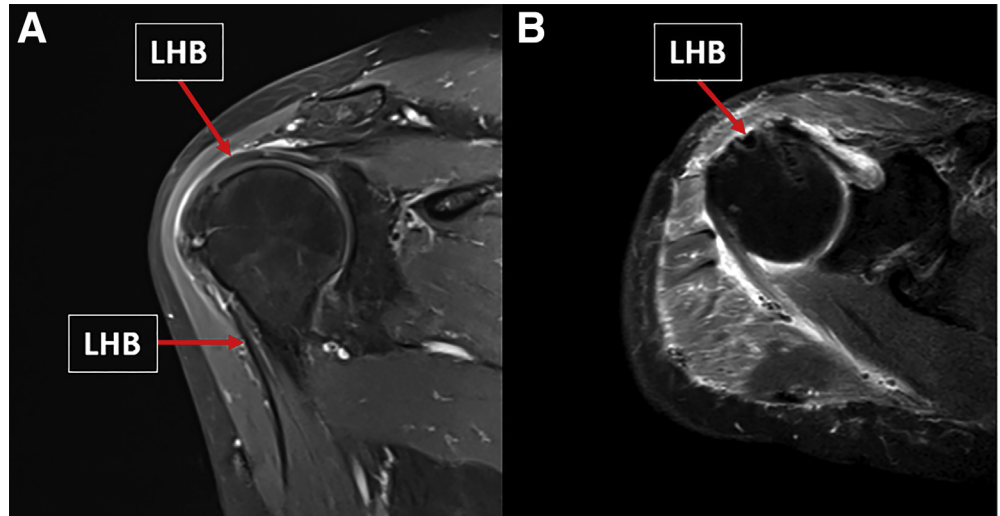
Rerouted long head of biceps (LHB) on magnetic resonance imaging (right shoulder): oblique coronal (A) and transverse (B) views.
